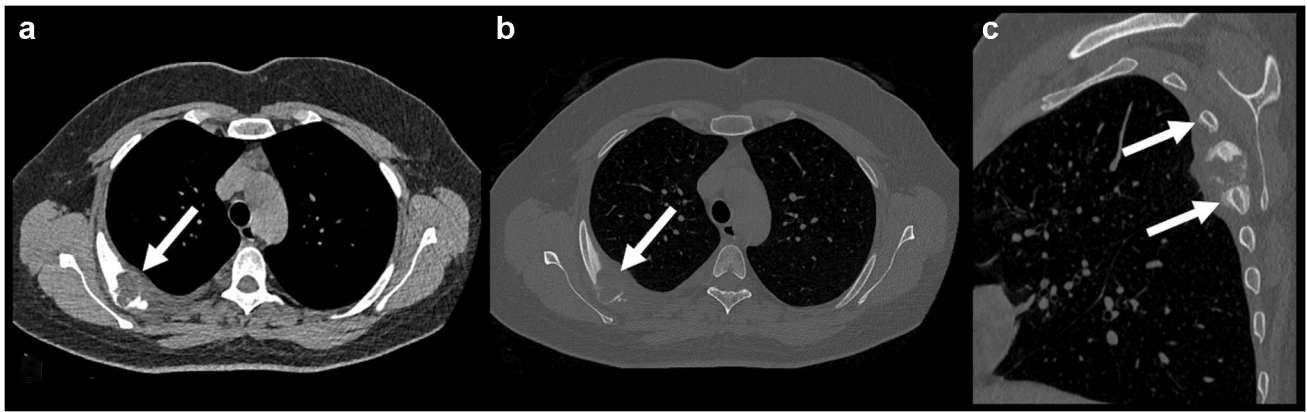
Right fourth rib osteoblastoma. Chest CT demonstrated an expansile lytic lesion in the posterior portion of the right fourth rib, in the mediastinal (arrow in a) and bone windows (arrow in b), causing cortical erosion, with extension to the adjacent soft tissues, associated
